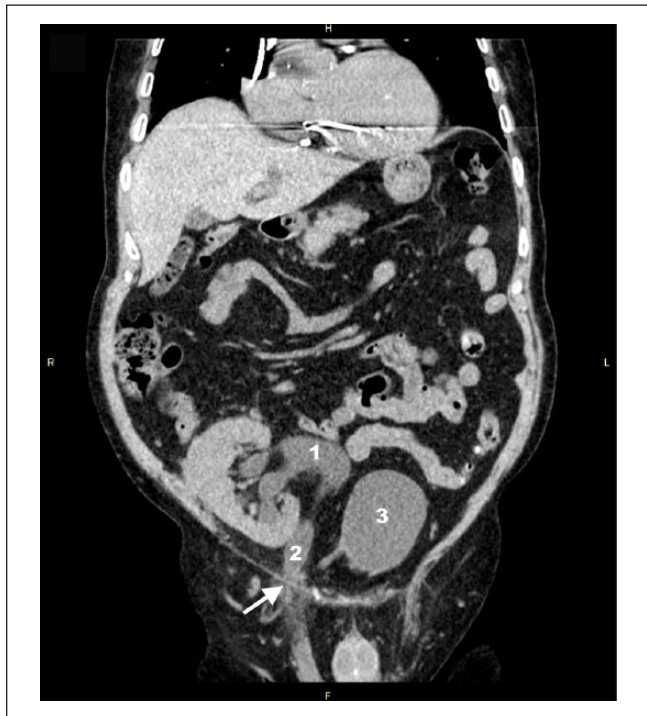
Abdominal computed tomography in coronal view, demonstrating moderate hydronephrosis (1), herniation of the transplant ureter (2) through inguinal ring (arrow), and the urinary bladder (3).
